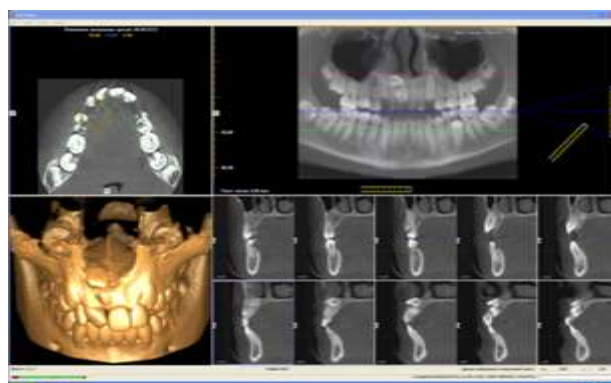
CBCT processed result.
